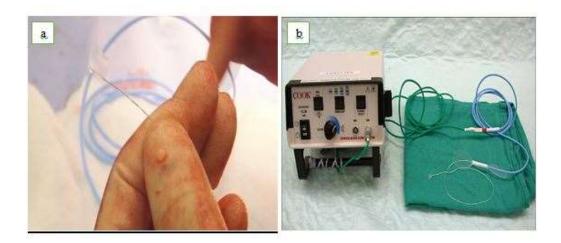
(a) Cook-Swartz<sup>®</sup> Implantable Doppler flow probe showing silicon cuff and flexible wire in the background (b) Cook-Swartz<sup>®</sup> Implantable Doppler flow probe, connecting wire and external monitoring device.
